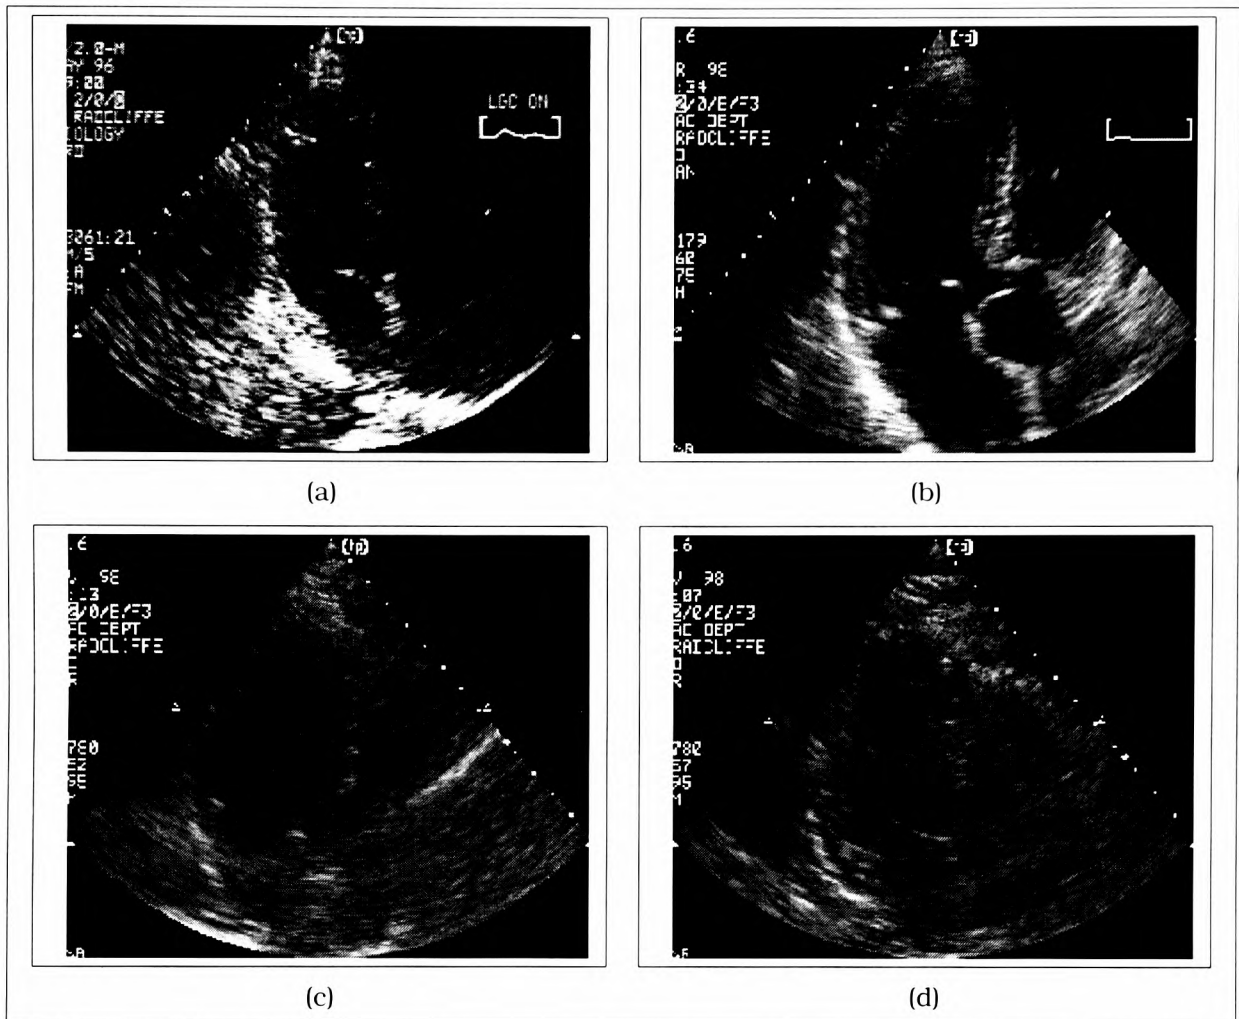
Echocardiographic images. Examples. Echocardiography is a non-invasive diagnostic method that utilizes high frequency sound to assess anatomical and functional abnormalities of the cardiovascular system. Four images are shown which convey the varying degree of difficulty the clinician has in making their assessment. They also show the challenging task we face in trying to model heart function. (a) A image digitised from a video recording. (b) A 'good' image acquired from one of the latest ultrasound machines; images can be stored digitally. (c) A stress echocardiography image of a patient at rest. (d) The same patient as in (c) at a peak dose of dobutamine. Note that displaying the echocardiographic image at a reduced size, as in the figure, reduces the visual effect of speckle noise.
